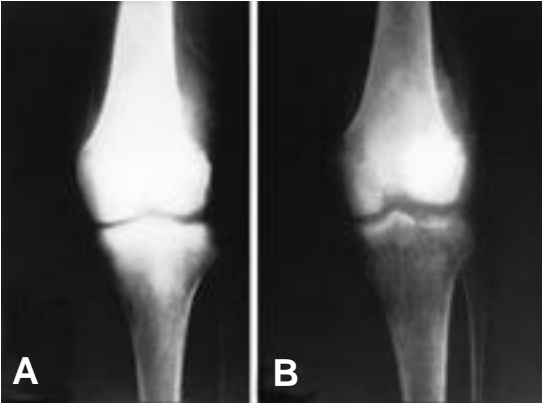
The simple X-ray shows irregular radio-opaque density, cortical destruction, and soft tissue extension before (A) and after (B) chemotherapy.
